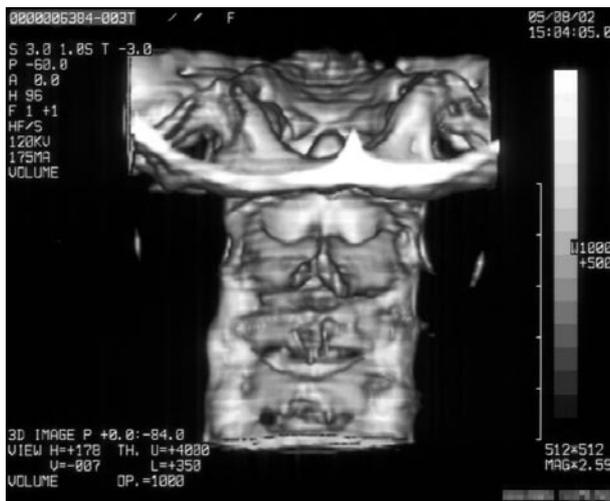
3D-CT scan of the craniocervical junction showing hypertrophic bony parts are the continuity of the occipital condyles.
